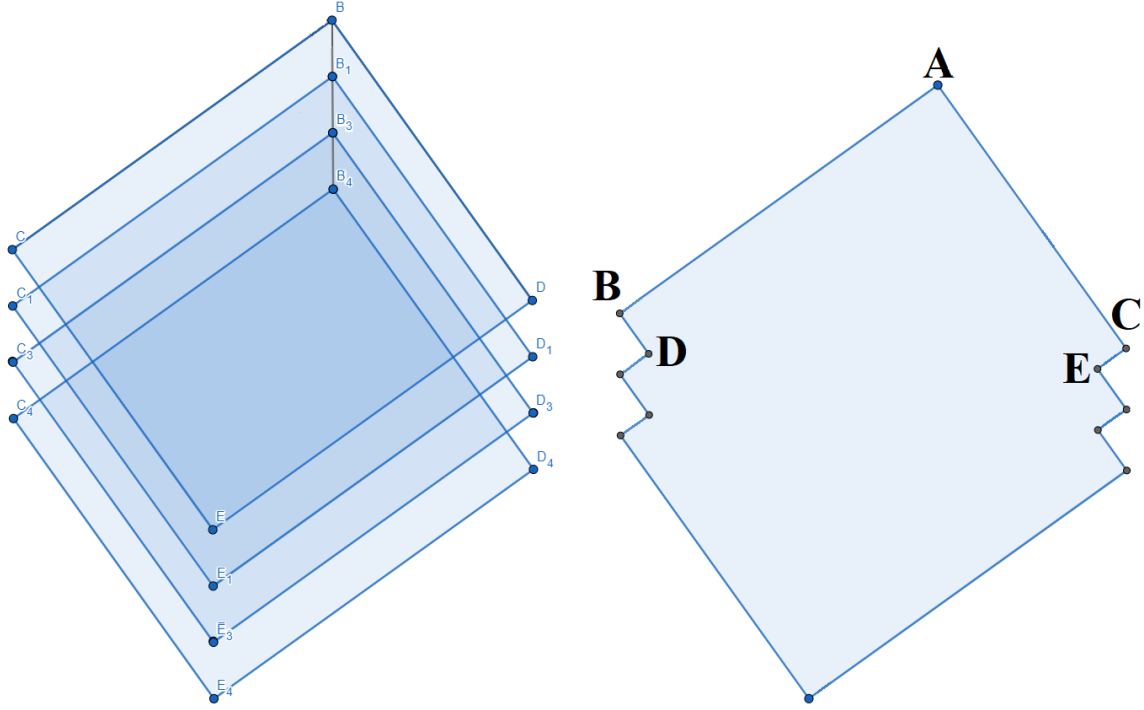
The stereo overlap produced from the apical column of ultrasound transducers. The left image shows the total view of the four transducers while the right image is only the stereo overlap minus the non-overlapped areas (the lightest top and bottom portions).
